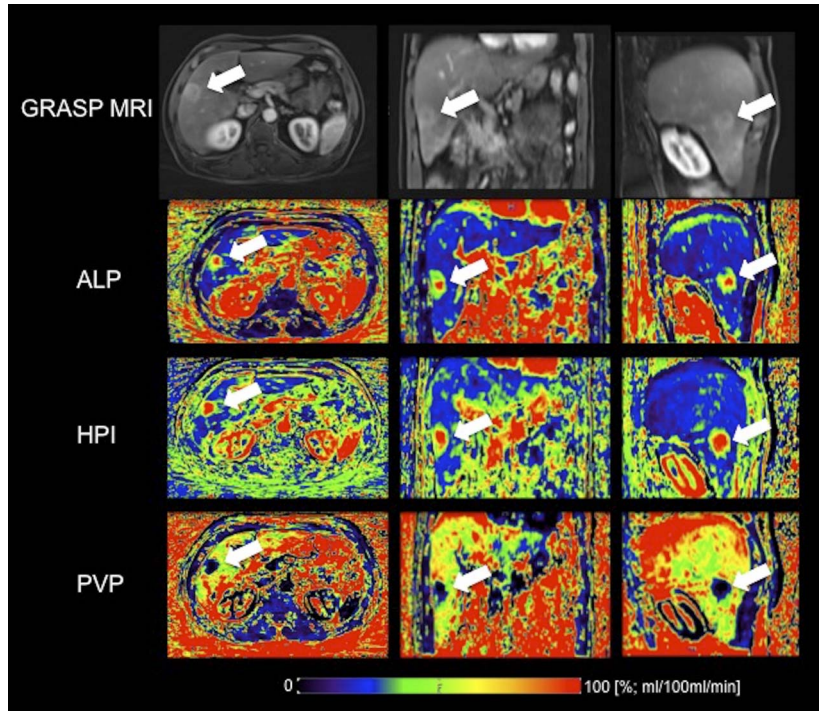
Morphological GRASP MRI images and perfusion maps of a 54-year-old male patient with a hepatocellular carcinoma (arrow) before TACE. The target lesion is clearly visible in the arterial phase GRASP MRI images and the perfusion maps. In the lesion periphery, partial volume effects are seen, which may result in underestimation of HPI. GRASP MRI indicates golden-angle radial sparse parallel MRI; TACE, transarterial chemoembolization; ALP, arterial liver perfusion [mL/100 mL/min]; HPI, hepatic perfusion index [%]; PVP, portal liver perfusion [mL/100 mL/min].
